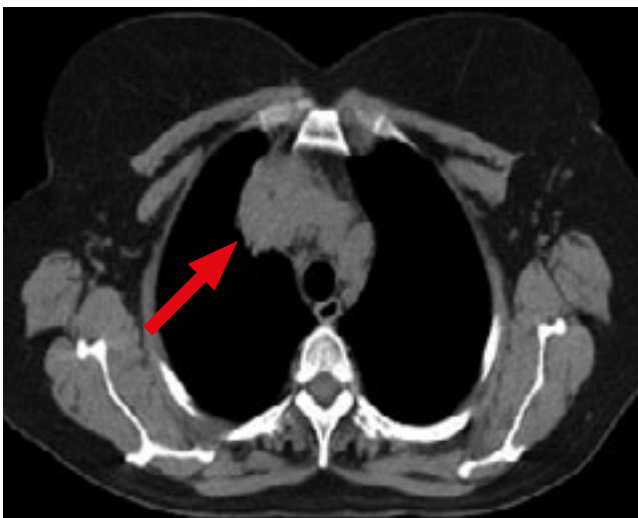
Thoracic CT scan with contrast medium - August 2013
